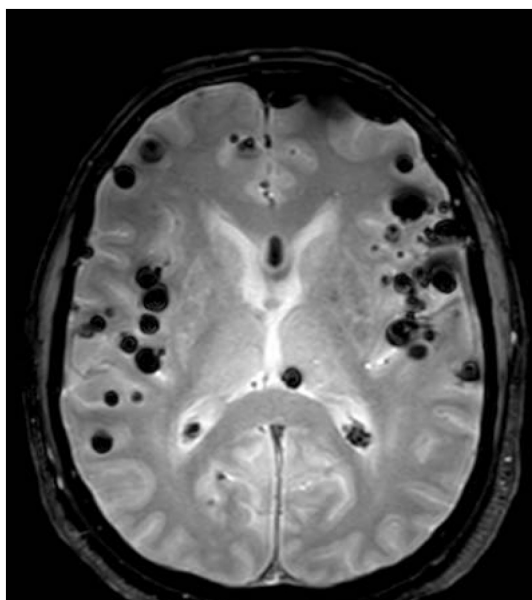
Axial T2-weighted brain MRI showing multiple extra-axial air bubbles seen diffusely throughout the brain subarachnoid spaces indicating pneumocephalus.
